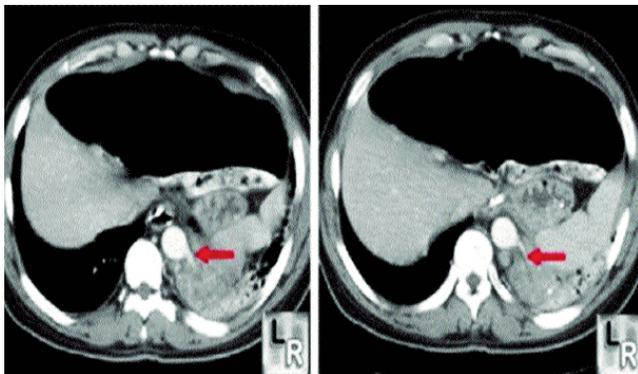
Contrast enhanced CT scan of patient. Red arrows are pointing towards a vessel which is arising from aorta and supplying sequestered lung portion.
